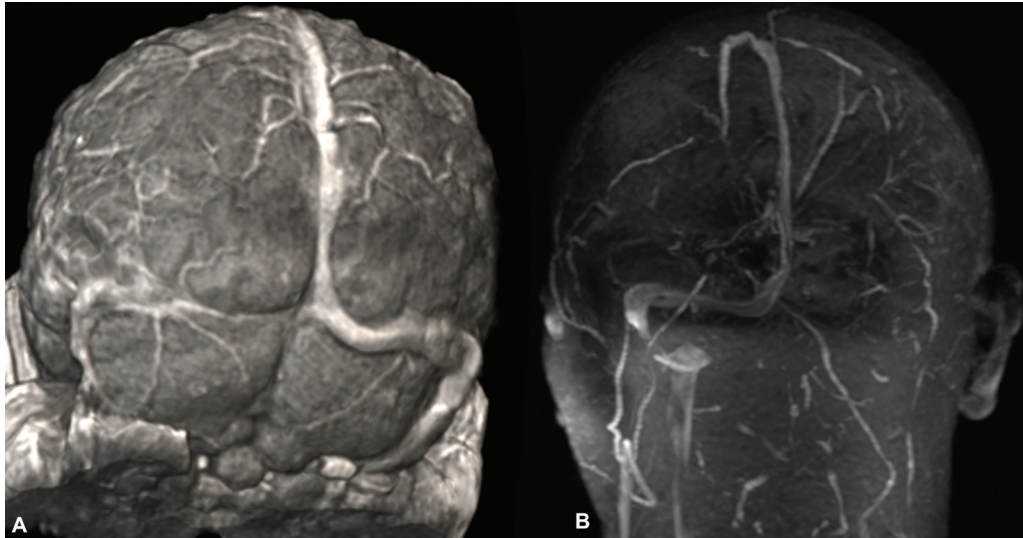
(A, B) Postgadolinium MRI also revealed a small caliber of the left transverse and sigmoid sinus, which was initially thought to be hypoplasia (A). Postoperative follow-up MRV subsequently confirmed thrombosis in the left vein of Labbe extending into the ipsilateral transverse and sigmoid sinus and internal jugular vein (B).
